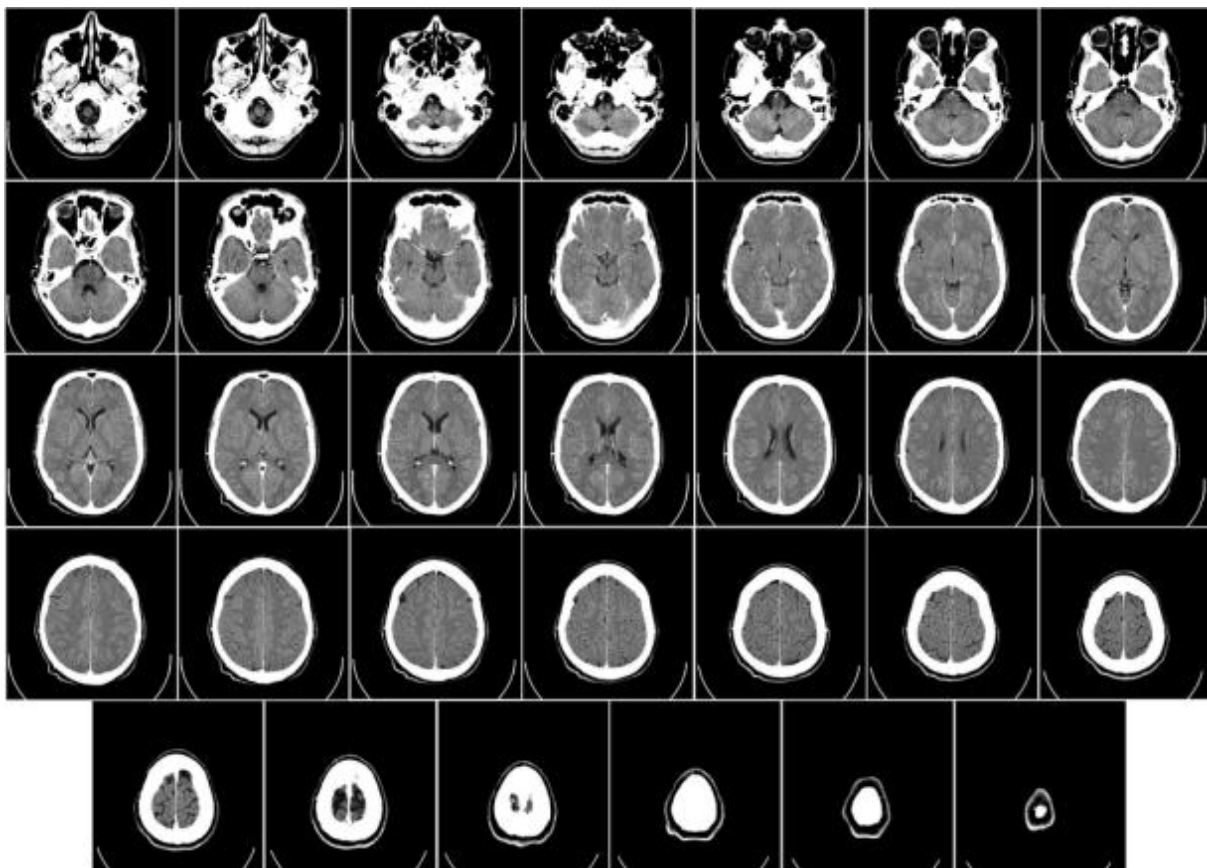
CT scan of the head (Image by Michael Häggström, Wikimedia Commons.)
